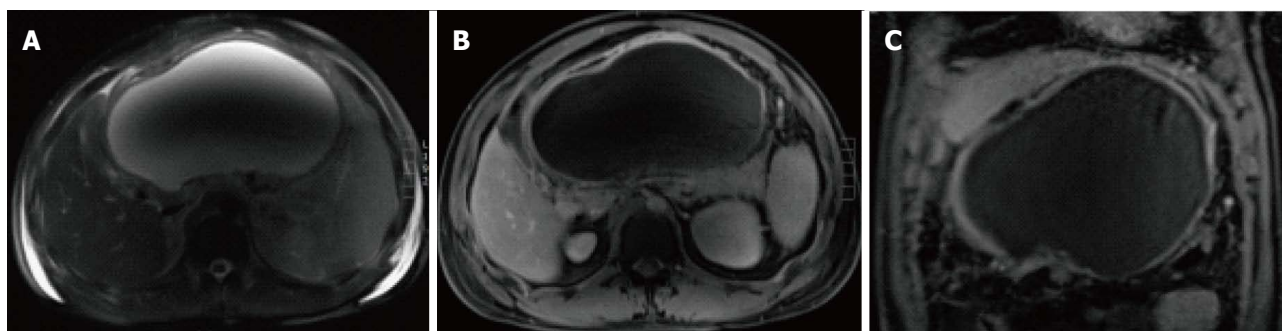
Large pancreatic pseudocyst. A: Axial fast spin-echo T2- weighted image with fat-suppression; B-C: Axial and coronal post-contrast 3D- GRE T1-weighted images with fat-suppression during the portal venous phase. There is a very large thin-walled cyst (A) within the lesser sac; which demonstrates mild uniform wall enhancement (B-C) in keeping with a large pancreatic pseudocyst. The central drop of signal on (A) is related to dielectric shading artifact.
